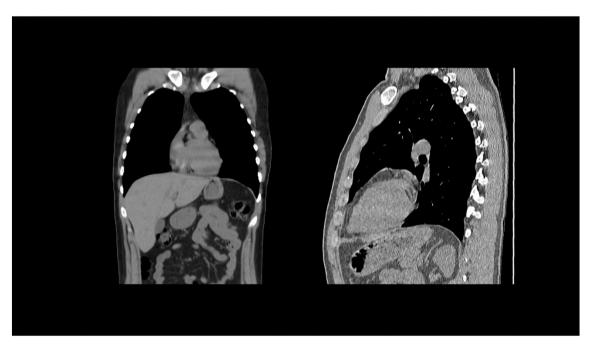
CT-scan control 12 months after primary repair with no evidence of hernia recurrence.
